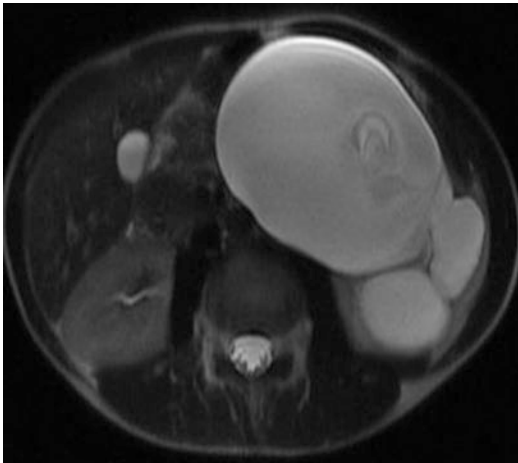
Huge UPJ obstruction discovered after an abdominal trauma (US was performed first, not shown) in a 15 year-old patient. MR imaging T2-weighted sequence; huge pyelo-ureteral dilatation
